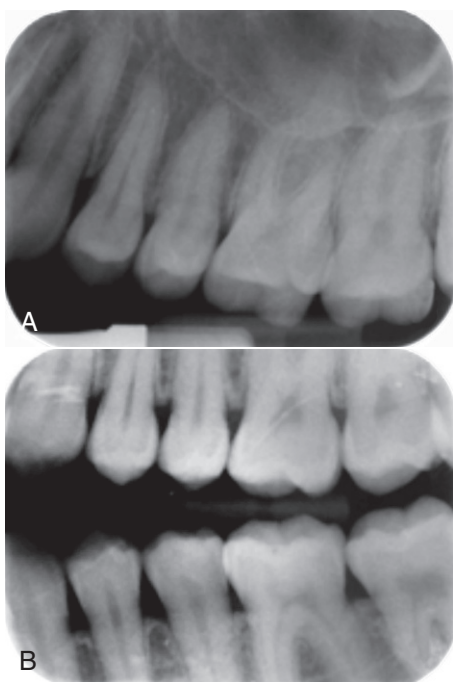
A, Periapical radiograph of maxillary left first molar area.
